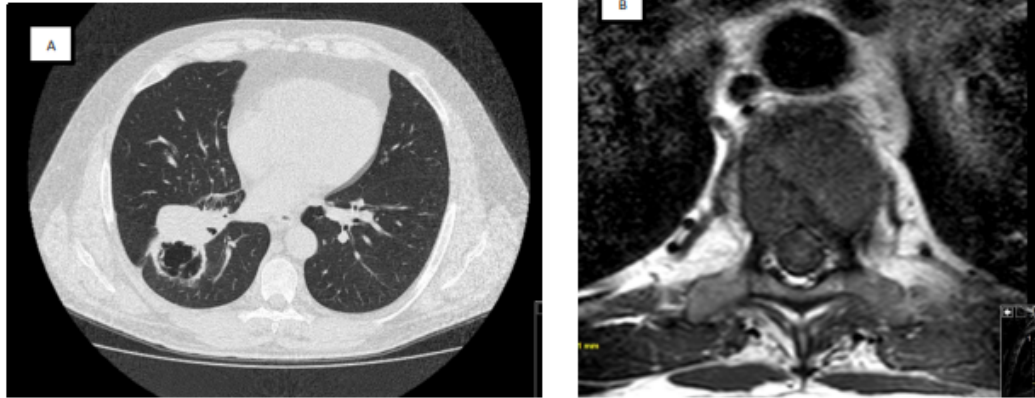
Chest computed tomography (axial view) showing right upper lobe mass at diagnosis (A); lytic lesion in D9 vertebral body detected by magnetic resonance imaging of the spine (B).
